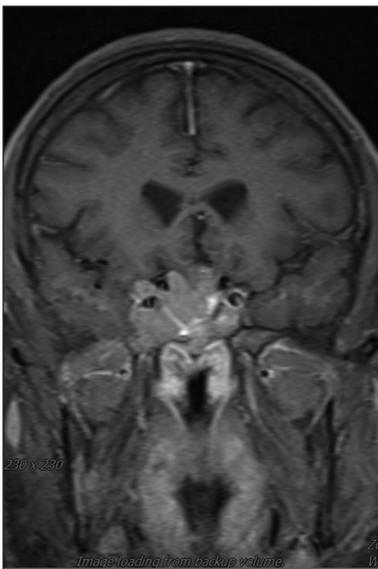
Coronal T1 weighted contrast-enhanced magnetic resonance imaging (MRI) of a 51-year-old man. A huge intrasellar mass lesion extending to the third ventricular region and encasing both cavernous carotid arteries is present. The patient was p53 positive.
